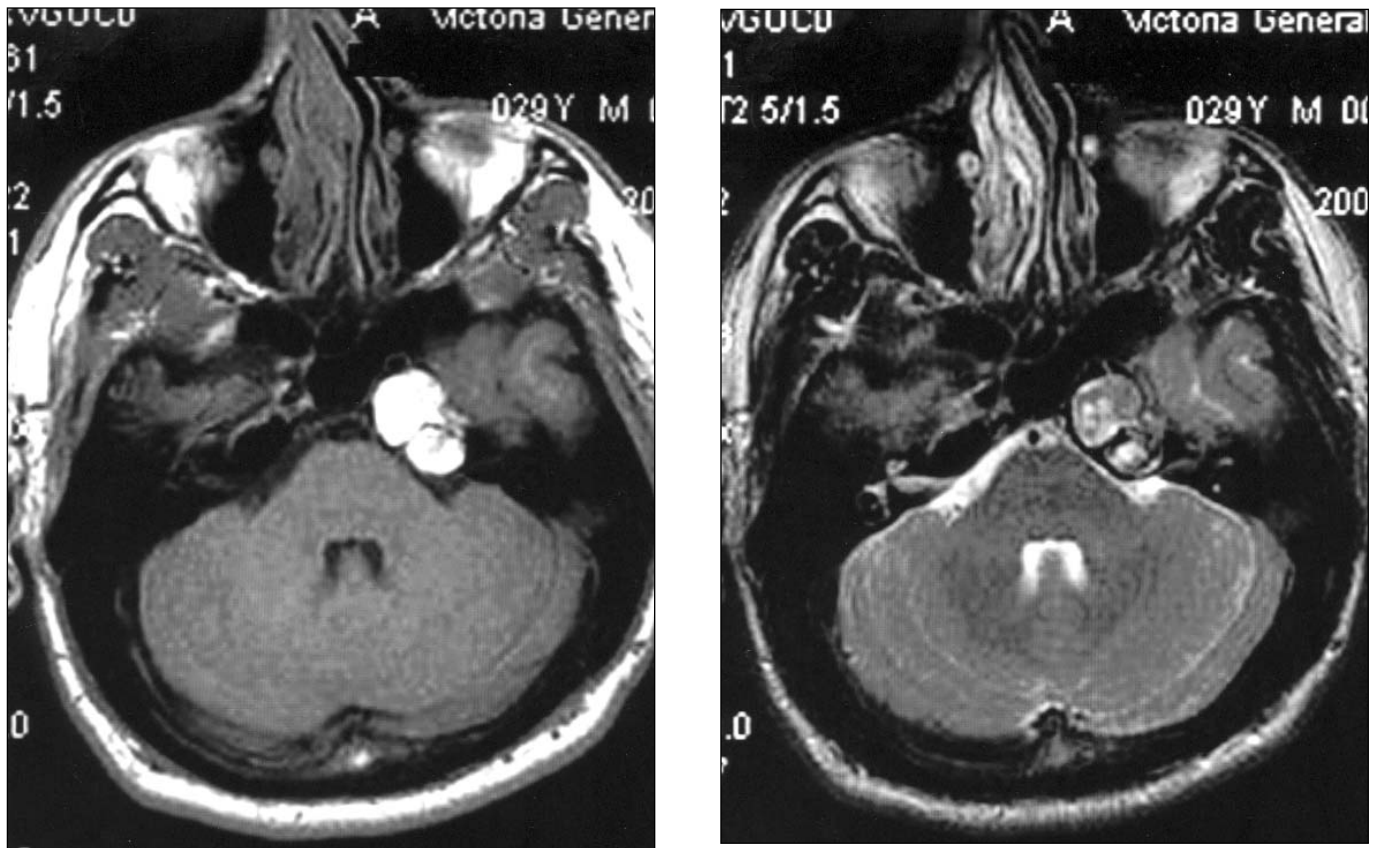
MRI scans with T1 (a) and T2 (b) sequences showing a predominantly high signal lesion involving both petrous apices.
